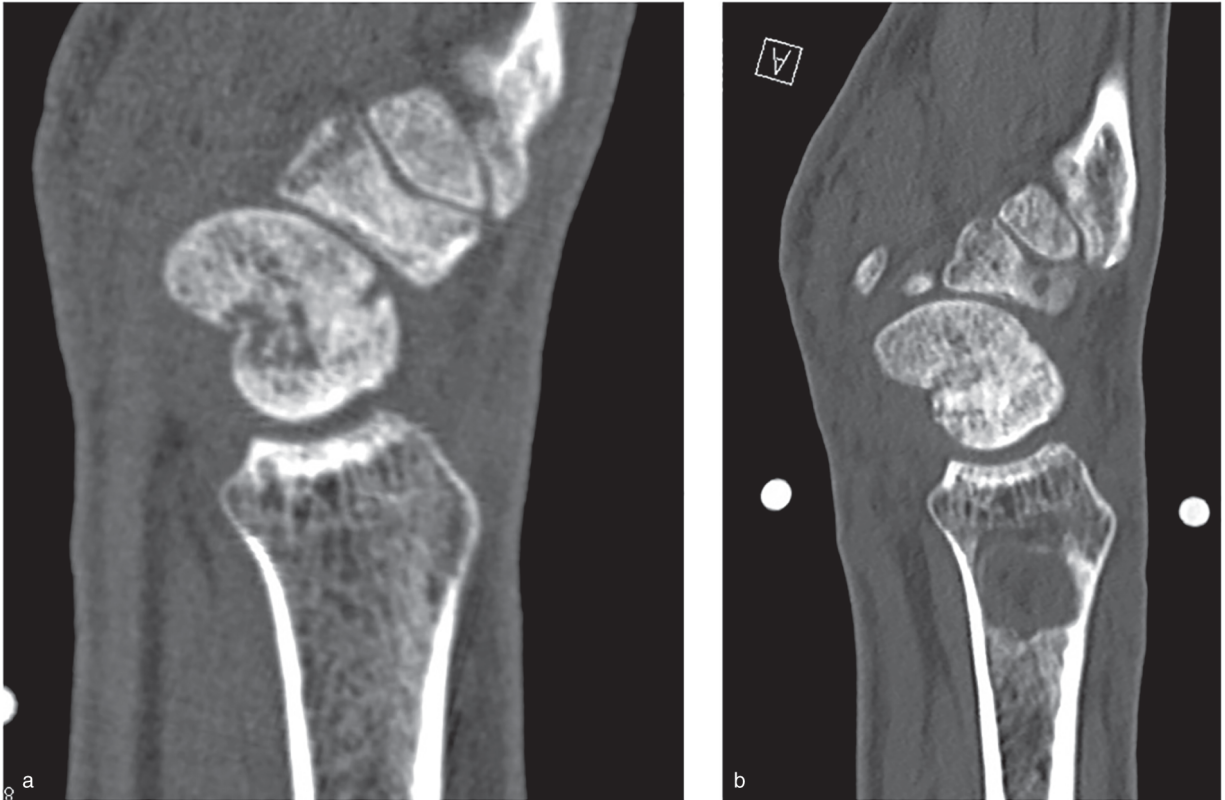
Resolution of clinical scenario: scaphoid reconstruction with a corticocancellous bone graft. (A) Preoperative sagittal CT image of the wrist shows a tendency toward a humpback deformity. (B) The patient is treated with a nonvascularized corticocancellous graft of the distal radius. The postoperative CT, three months after surgery, demonstrates improvement in scaphoid height and near complete consolidation.
